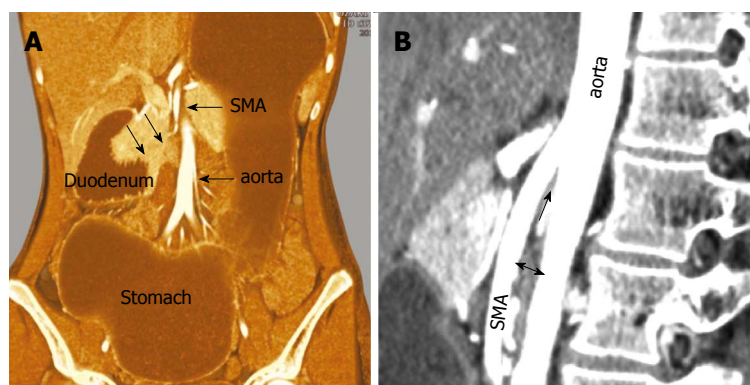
Abdominal computed tomography. A: A distended stomach and proximal duodenum were shown with caliber change at the third portion (arrows), between superior mesenteric artery (SMA) and aorta; B: On the sagittal view, the aorto-mesenteric angle was 10° (arrow) and the aorto-mesenteric distance (two-head arrow) was 5.5 mm.
